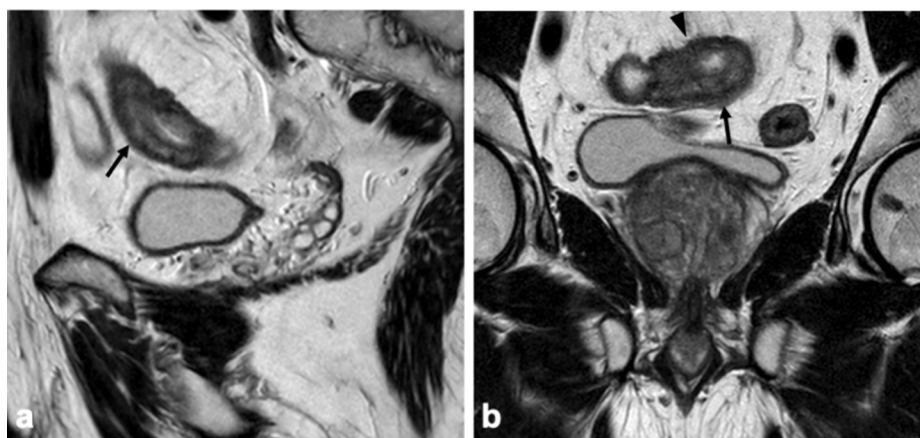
Sagittal (a) and coronal (b) T2w images show terminal ileum wall thickening (arrows). Note the fibrofatty proliferation and the comb sign (arrowhead in b); Crohn's disease was then confirmed. T2w T2-weighted.
